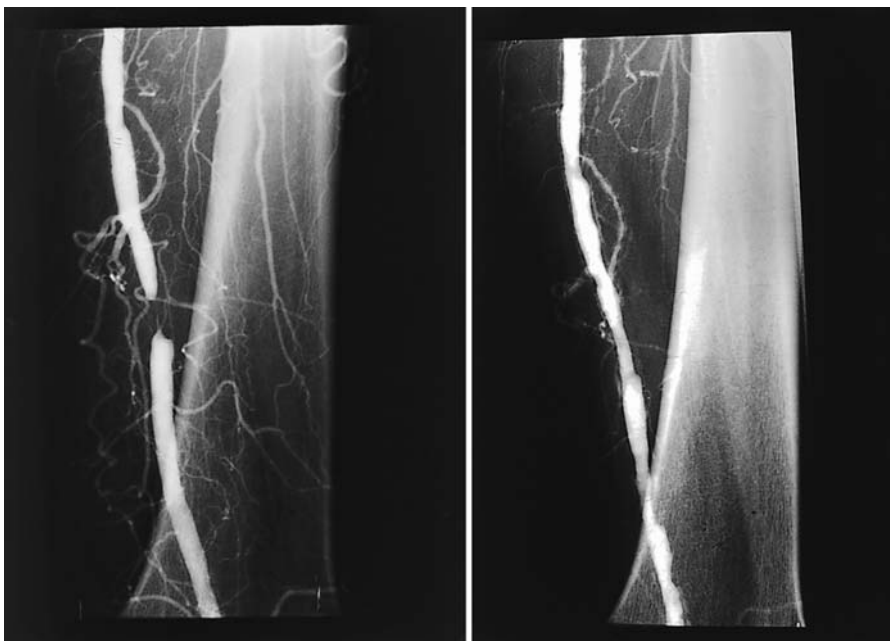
Radiograph of atheromatous narrowing.
